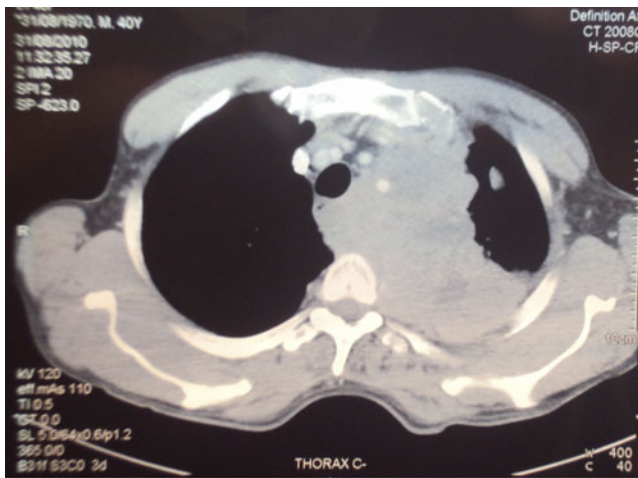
CT scan of tumor mass in the superior lobe of the left lung
